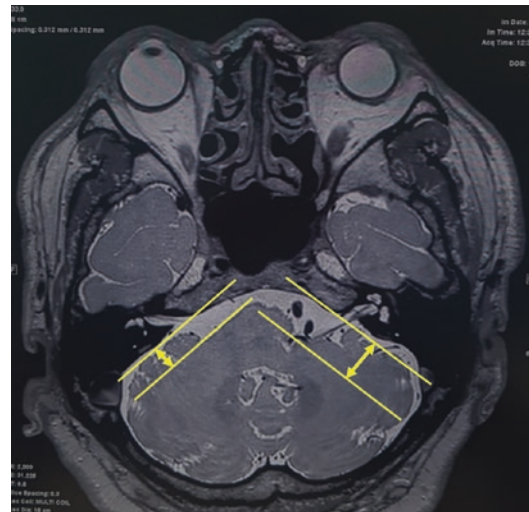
A preoperative MRI showed the left vertebral artery and posterior inferior cerebellar artery in close proximity to the root exit zone of the ipsilateral facial nerve, and the vertical distance of cerebellar retraction was more than 10 mm. View of measured vertical length from the petrous temporal bone to neurovascular compression point. The greater the amount of retraction, the greater the damage to the cochlear nerve
